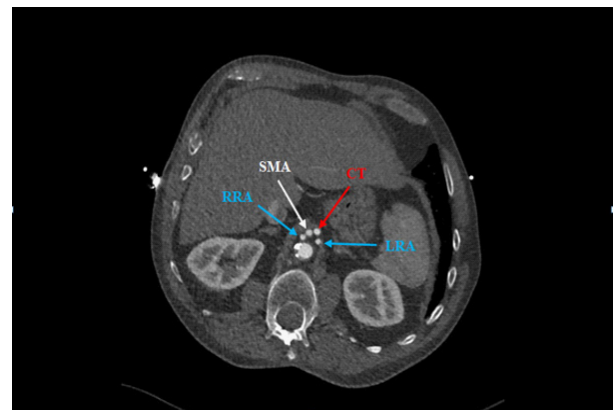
CT examination of the abdomen, axial view – a typical location of the ostium of the visceral arteries (CT, SMA, RRA, LRA) above the level of the diaphragm. Scan view on the level of the aortic hiatus of the diaphragm.
